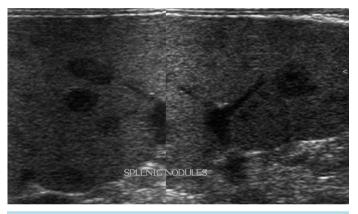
HIV-TB coinfected patient with CD4+ T-cell count of 122 cell·mm⁻³ with no abdominal symptoms. Sonograms of the spleen shows multiple small intraparencymal illdefined masses less than 10 mm.
